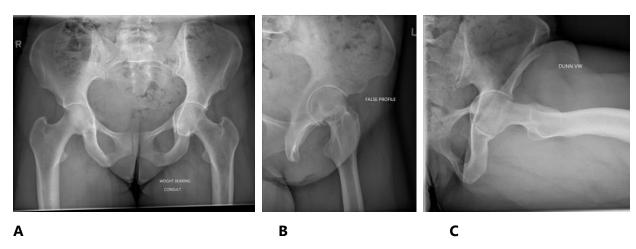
Representative hip X-ray series taken in 2022 (A: Weight bearing anteroposterior (AP), B: False profile, C: Dunn view). Femoral head crossing the ilioischial line on AP pelvic radiograph with joint space narrowing and early arthritic changes. Provided and published with consent from the case subject.
